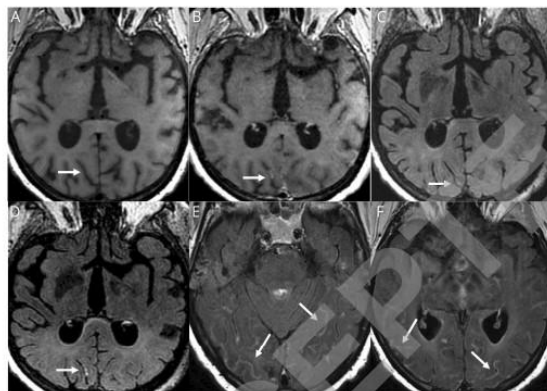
Leptomeningeal enhancement. Axial T1 before (a) and 5 minutes after contrast (b), axial FLAIR before (c) and immediately after contrast (d), delayed (10 minutes) after contrast axial FLAIR weighted MR images (e,f). Woman aged 77 years : diffuse leptomeningeal linear FLAIR and T1 contrast enhancement (arrows), not visible on pre-contrast T1 and FLAIR (arrows), but better seen on delayed after contrast FLAIR weighted MR images (e,f).
